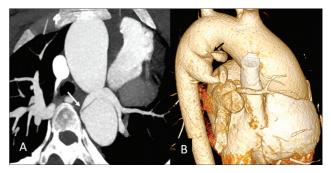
Computed tomogram angiography in an adult patient with congenital heart disease shows (A) large aortopulmonary collateral artery (APCA) with tight stenosis (white arrow) at its origin from descending thoracic aorta. (B) The anatomy is better defined in virtual reconstructed images in right anterior oblique projection, large APCA with tight ostial stenosis (black arrow).
